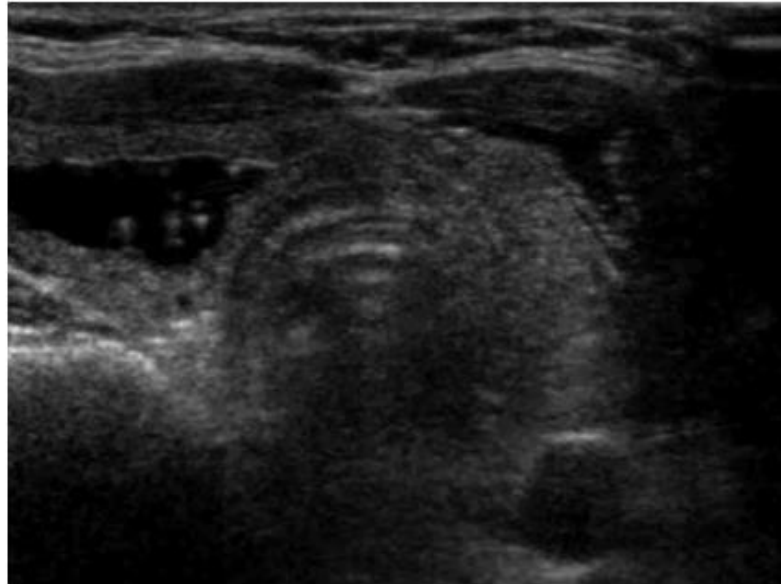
43-year-old woman with viscous cystic thyroid nodule. Axial sonogram of neck after aspiration shows volume of viscous cystic thyroid nodule has decreased significantly.
